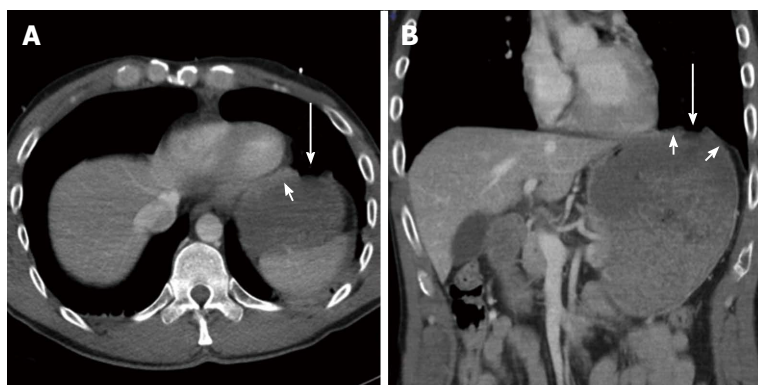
Computed tomography findings in blunt diaphragmatic lesions - segmental defect. These 3 mm thick axial (A) and coronal (B) multiplanar reconstructions show a segmental diaphragmatic defect (arrows) surrounded by diaphragmatic thickening that indicates muscle retraction (arrowheads).
